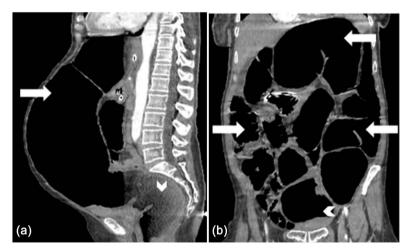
Abdominal CT in coronal and sagittal sections, showing the dilatation of all of the colon (arrows) and rectum (arrowhead), without sharp transition or mechanical obstruction.
